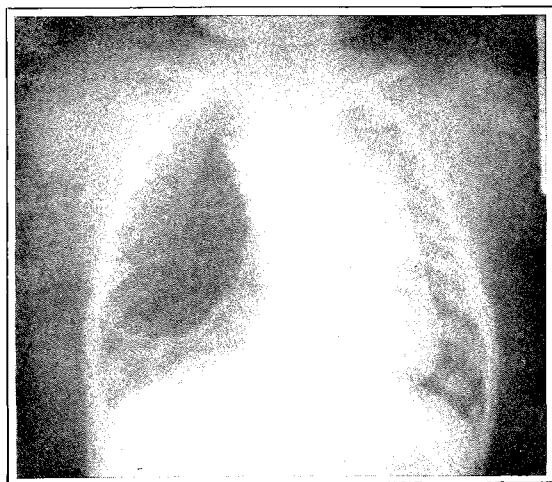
Chest radiograph at four months showed large pneumatocele in the right lung field.
